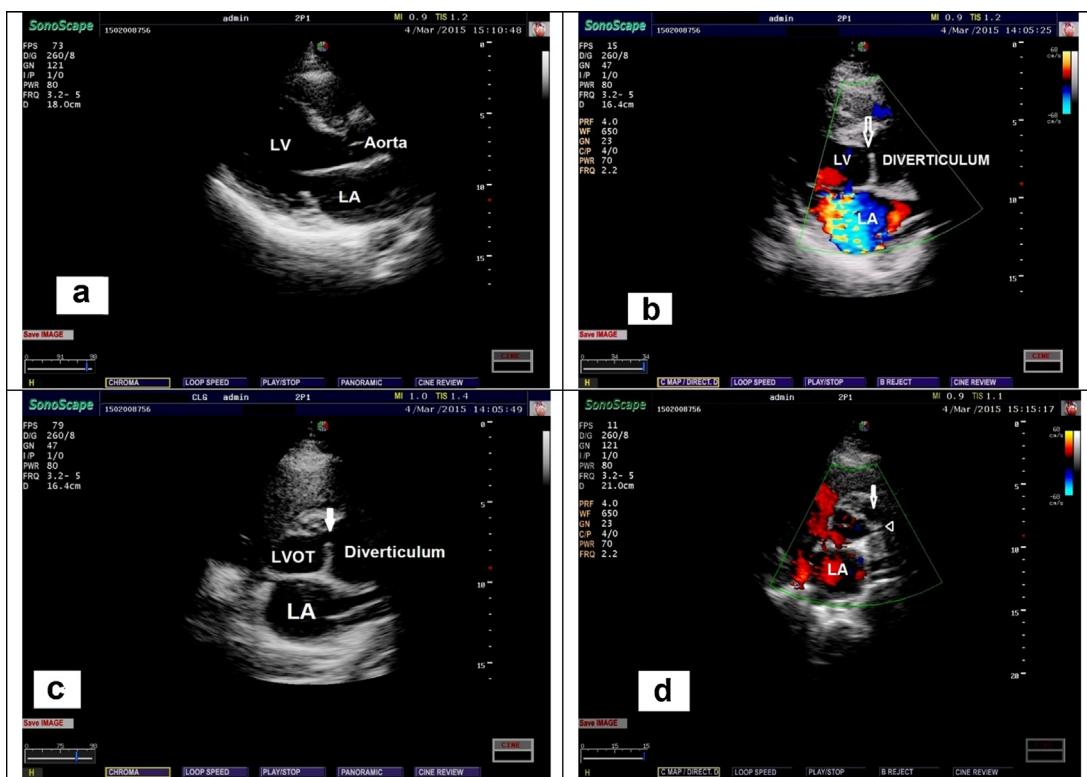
Echocardiogram images. (a) Normal PLAX view does not reveal any abnormality. (b) PLAX with lateral tilt shows a pouch (arrow) with connection to the LVOT region. (c) Short axis view (SAX) below the aortic valve reveals a chamber (arrow) with a connection to LVOT. (d) SAX view shows the diverticulum (arrow) in relation to the left main coronary vessel (arrow head).
